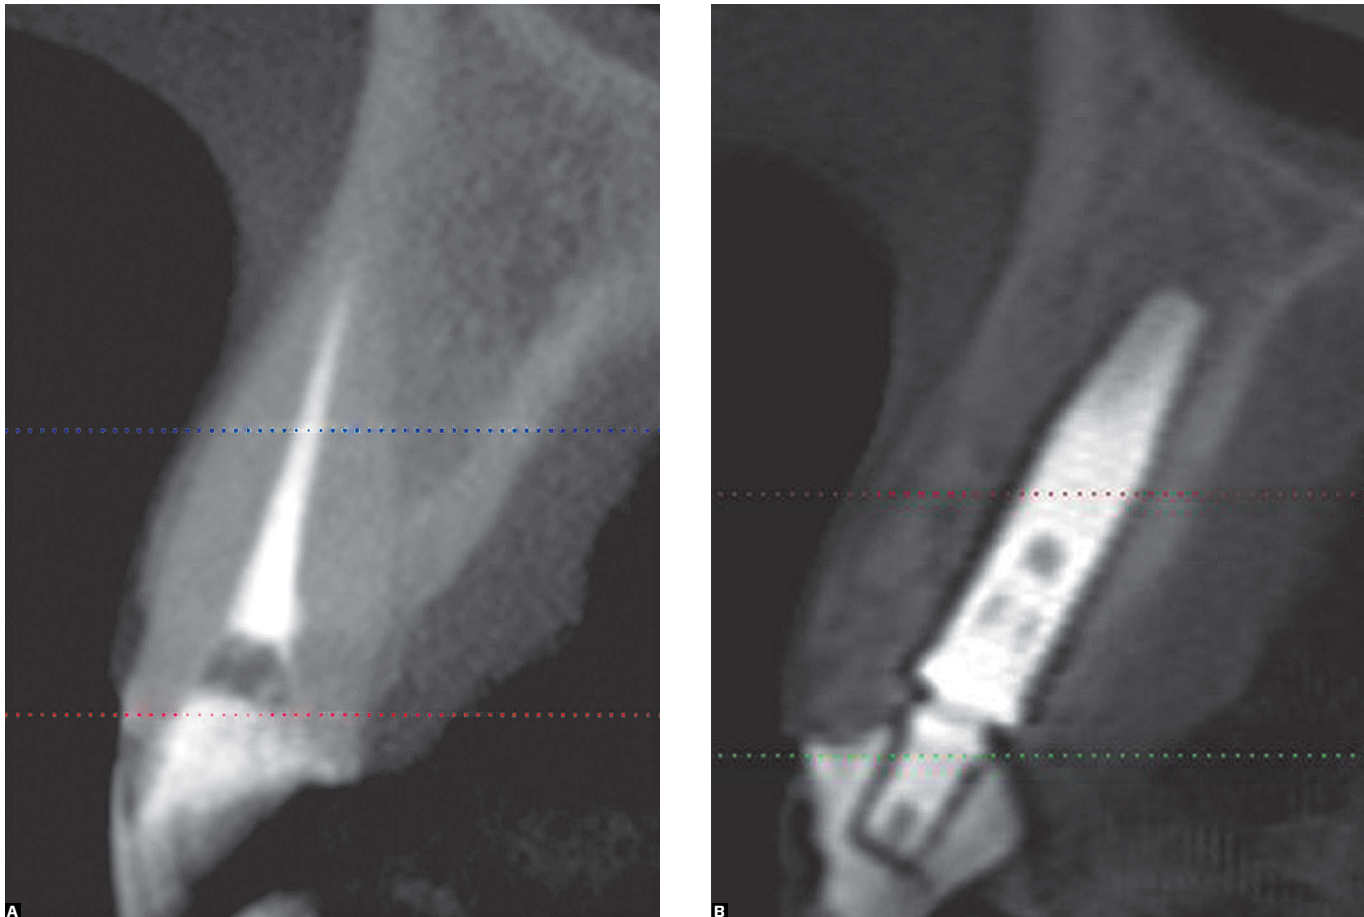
A) Initial tomographic image. B) CBCT one year after final crown. Note appropriate bone volume around the implant, particularly in the buccal cortical zone.
